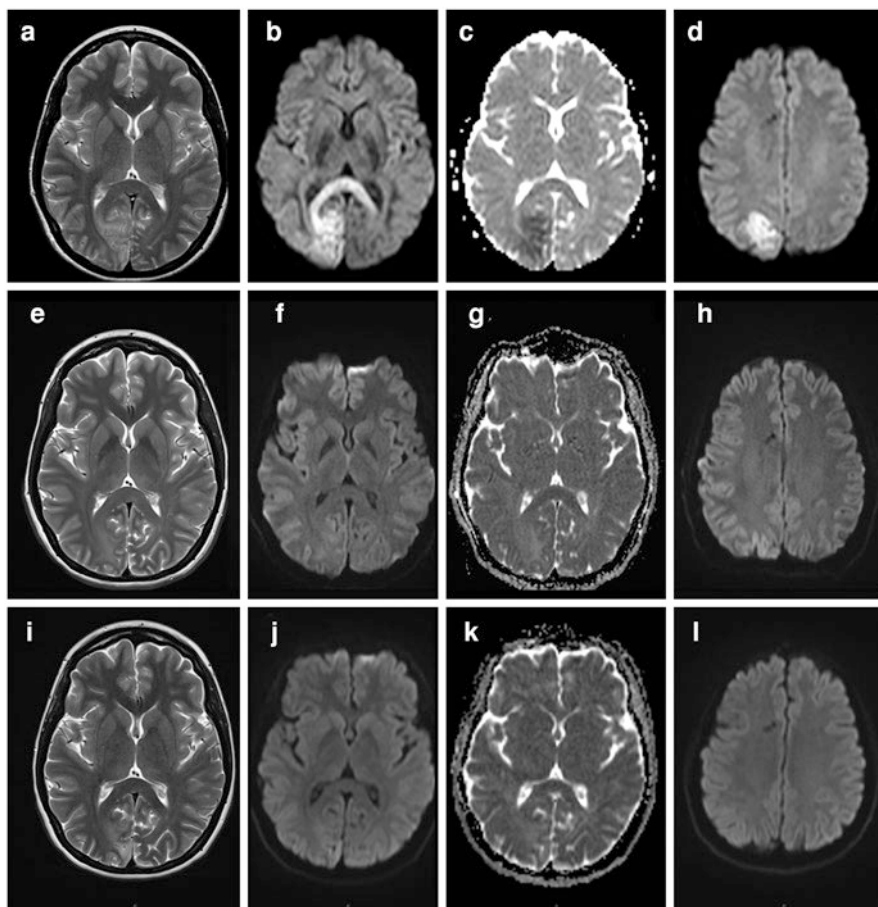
Serial MRI scans from the patient described in case vignette 2. a, e and i = T2-weighted image; b, f and j + d, h and l = Diffusion-weighted image (DWI); c, g and k = apparent diffusion coefficient (ADC) image
